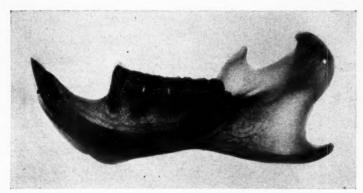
Radiograph of mandible of woodchuck.
